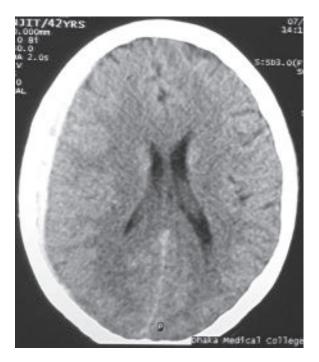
CT Scan of the brain axial view showing acute subdural haematoma (Right) less than 5 mm without midline shifting.
